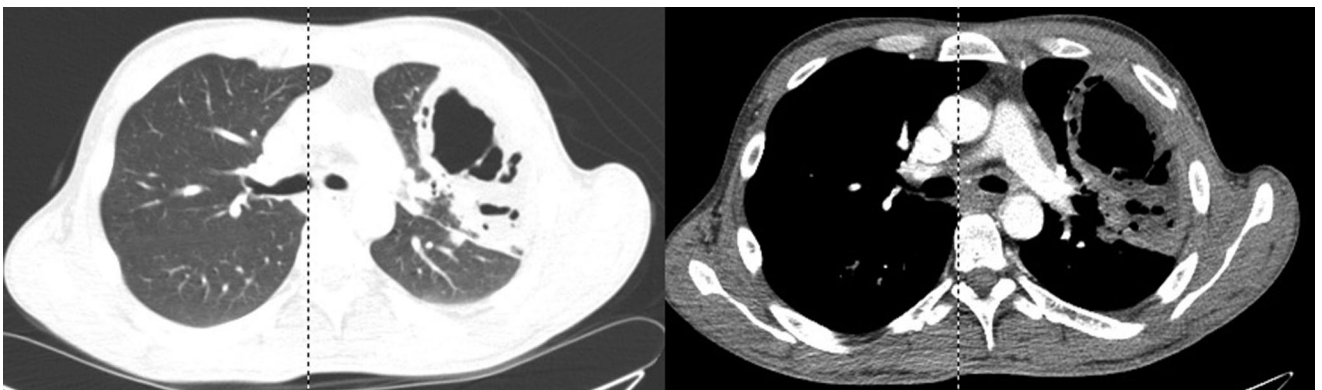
Computed tomography shows a 10 × 12 × 7 cm multiloculated air and fluid filled cavity with a heterogeneously enhancing wall in the left upper lobe, and atelectasis and consolidation in the surrounding lung parenchyma.
